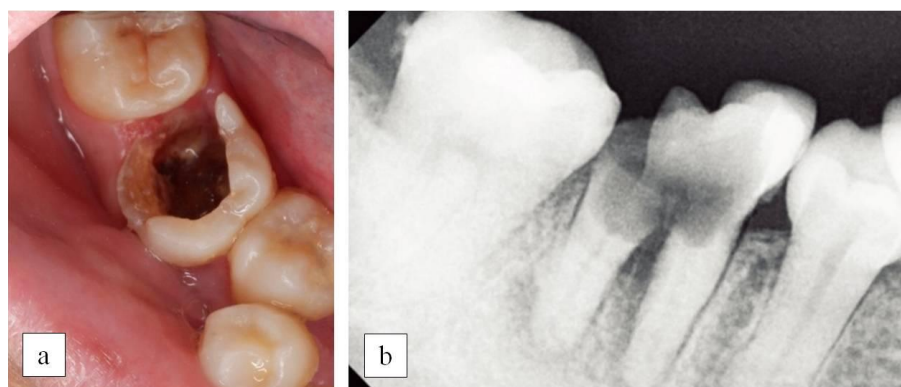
(a) Clinical view of tooth 46 before treatment; (b) Pre-operative radiographic image of tooth 46.
